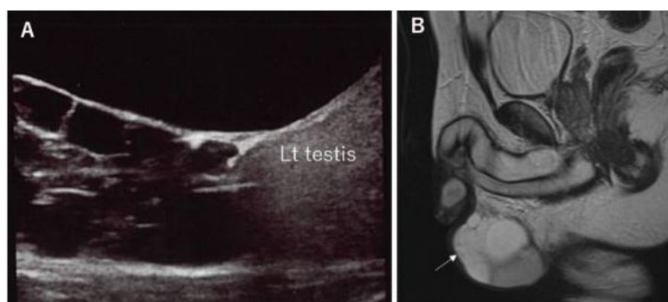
(A) Longitudinal sonogram of the left scrotum reveals multiple cystic spaces at the upper part of the left testis. (B) Longitudinal section of MRI shows multiple cystic masses (allow) in the upper part of the left scrotum.
